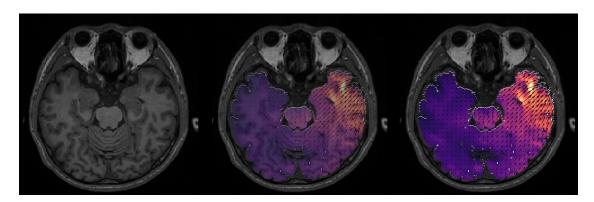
Electric field layered on MRI, shown with opacity 0, 0.3 and 1. Visualization created for this project.
